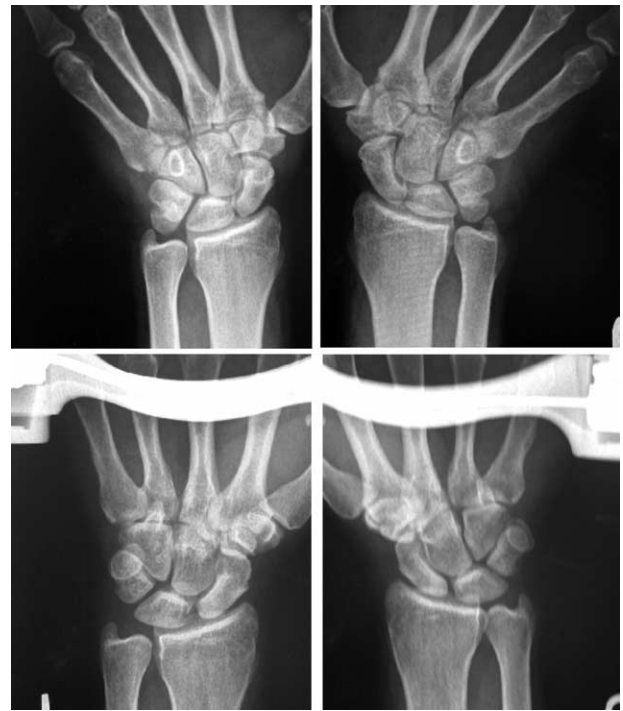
Comparative PA neutral (top) and grip-view (bottom) radiographs of patient 8. The patient is grasping a dynamometer on the grip-view radiographs. Dynamic SL instability is shown on the left wrist with SL interval gapping on the grip-view radiographs compared with the uninvolved right wrist.
